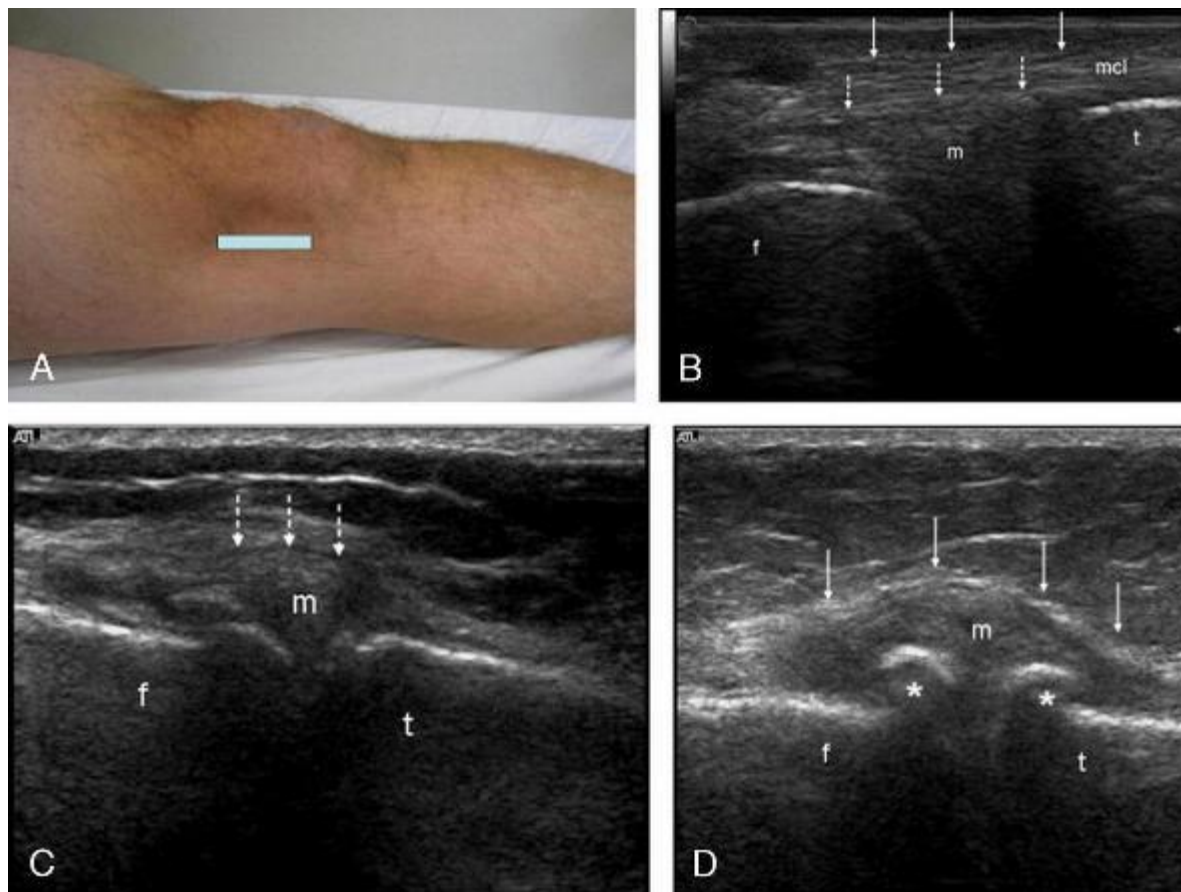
Longitudinal ultrasonographic images of the medial joint line (in black and white). A, Position of probe footprint. B, Ultrasonographic image of a normal knee shows distal femur (f), proximal tibia (t), triangular outline of the medial meniscus (m, dashed arrows), and the linear echoes produced by the medial collateral ligament (mcl, solid arrows). C, Ultrasonographic image shows medial meniscal extrusion (m, dashed arrows). D, Ultrasonographic image in knee OA demonstrates medial meniscal extrusion (m) with resulting displacement of the medial collateral ligament (arrows) and obvious osteophytes (*) proximal and distal to the joint line.¹⁴⁸ Reprinted with permission from Elsevier.
